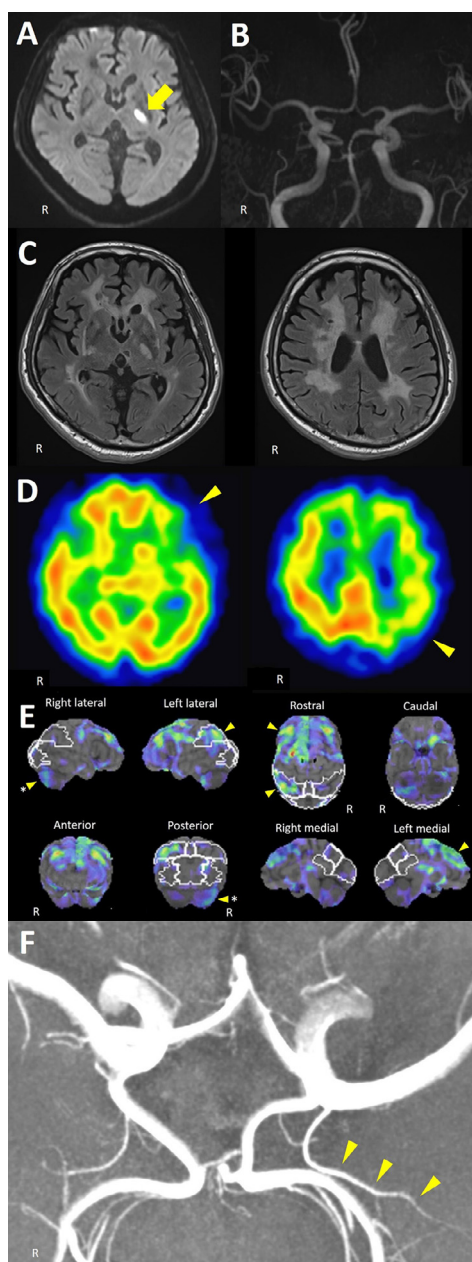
Brain magnetic resonance imaging (MRI) showing left acute anterior choroidal artery (AchA) infarction and N-isopropyl-p-[123I]-iodoamphetamine single-photon emission computed tomography (^{123}I -IMP SPECT) analyzed with three-dimensional stereotactic surface projection (3D-SSP) showing hypoperfusion in the left frontal and parietal lobes. Diffusion-weighted image on the day of admission revealed high intensity in the left posterior limb of the internal capsule (arrow) (A). 3 Tesla MRA on the day of admission showed intact large arteries, but it was difficult to evaluate the AchA (B). Flair attenuated inversion recovery image on the day of admission indicated old multiple microinfarcts (C). There was no apparent hypoperfusion in the thalamus. However, the hypoperfusion of the left frontal and parietal lobes on ^{123}I -IMP SPECT on the 13th day after admission indicated left thalamus involvement due to left acute AchA infarction (arrowheads) (D). Hypoperfusion in the left frontal and parietal lobes was revealed in 3D-SSP as well (arrowheads). Hypoperfusion in the contralateral cerebellum (asterisked arrowheads) can be explained through crossed cerebellar diaschisis, also known as Monakow's effect (E). High resolution 7 Tesla MRA with isotropic 0.25 mm resolution on the 15th day after admission demonstrated enhanced left AchA (arrowheads) (F). (Color version of figure is available online.)
